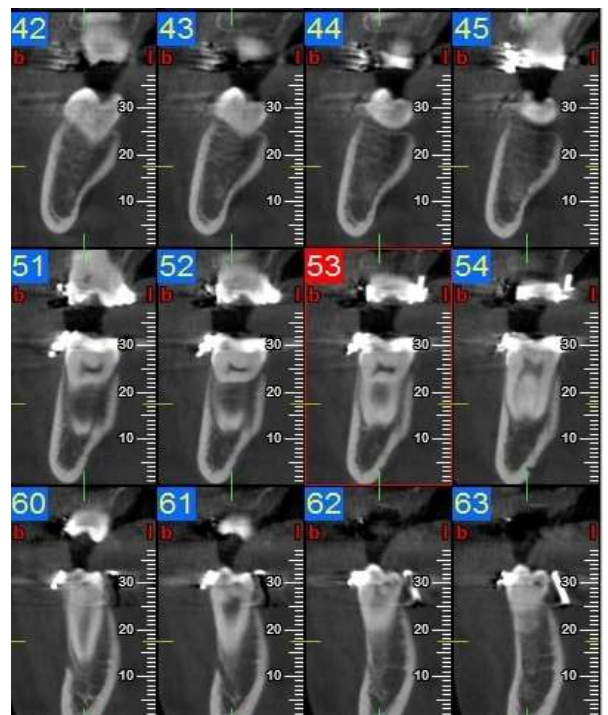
Showing the bilateral comparison of cbct of left & right side of molar region
